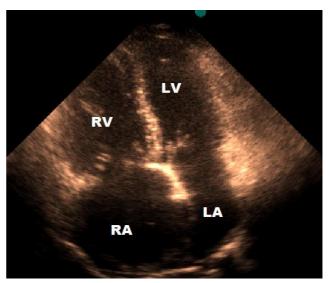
Trans-thoracic echocardiography demonstrates RV hypertrophy and enlargement of both right atrium and ventricle.
